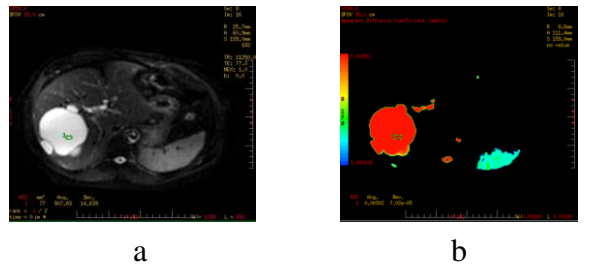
a) The axial DWI image showing hepatic cyst lesion with diffusion restriction, b) ADC of the same with ADC value as : $3.0 \times 10^{-3} \text{ mm}^2/\text{sec}$.
